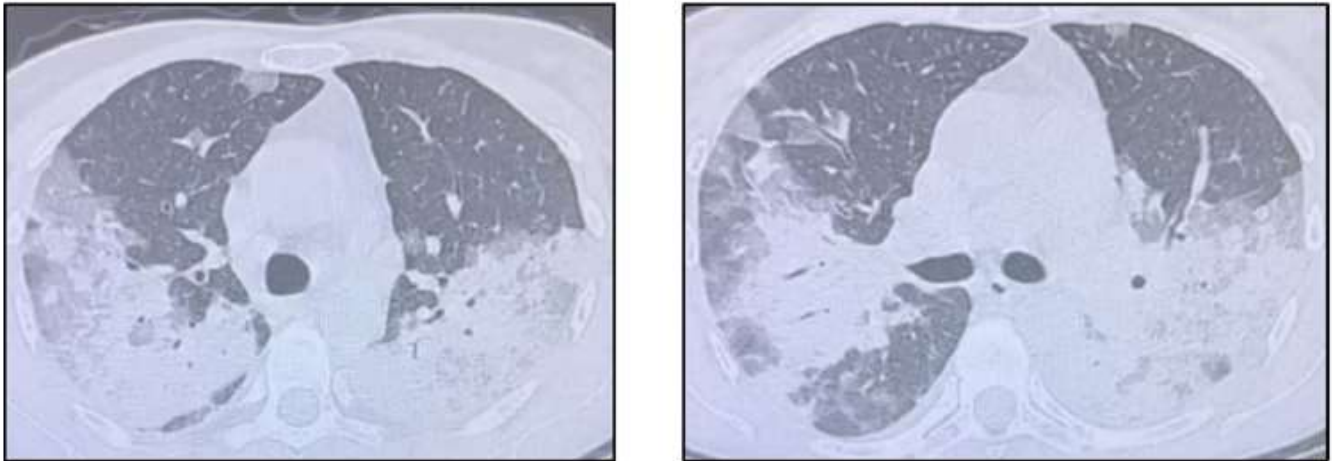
CT-scan at hospital admission: presence of multiple areas of ground glass opacity mixed with areas of parenchymal consolidation at the lung bases
